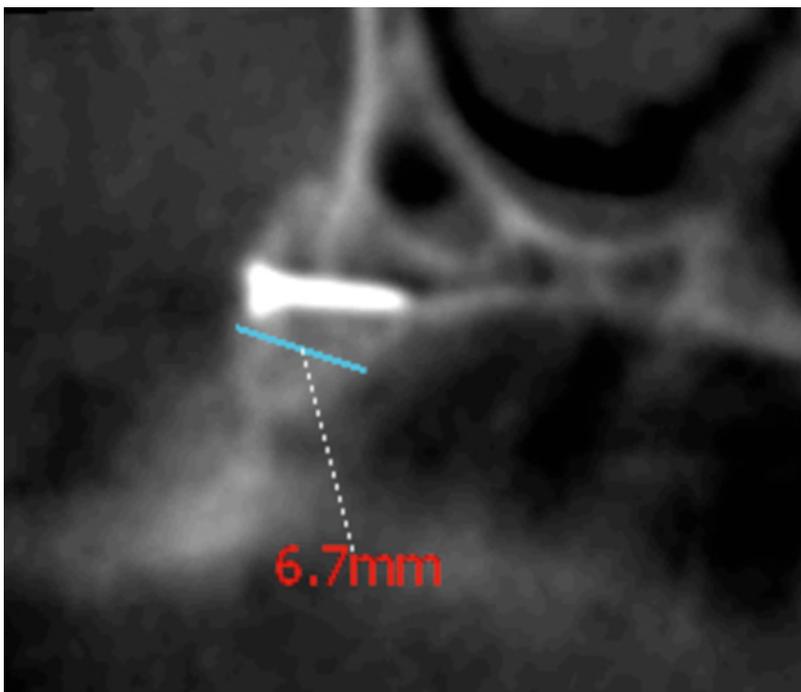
Postoperative CBCT showing axial view of the ridge at #11 site, with the integrated block graft and increased ridge width.
